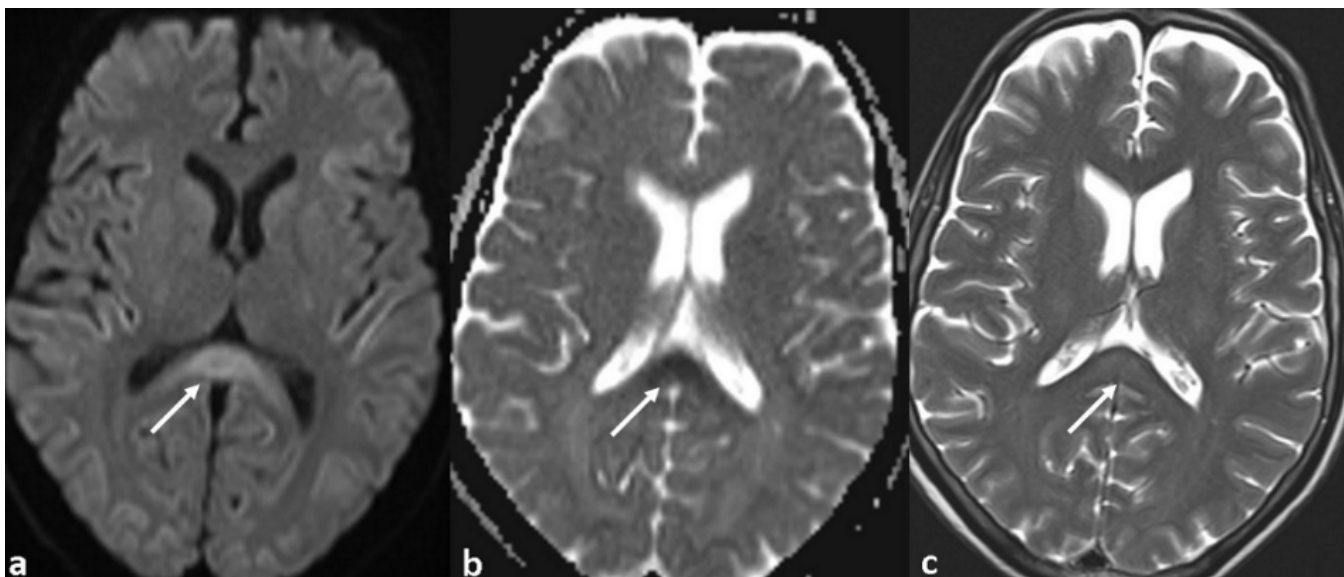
(a, b) Drug induced isolated corpus callosum splenium lesion is shown; localized diffusion restriction seen as hyperintense signal on DWI and confirmed with hypointense signal on corresponding ADC maps, representing isolated splenial ex-cytotoxic edema. (c) On axial T2WI, splenial subtle hyperintensity can be depicted (arrow).
